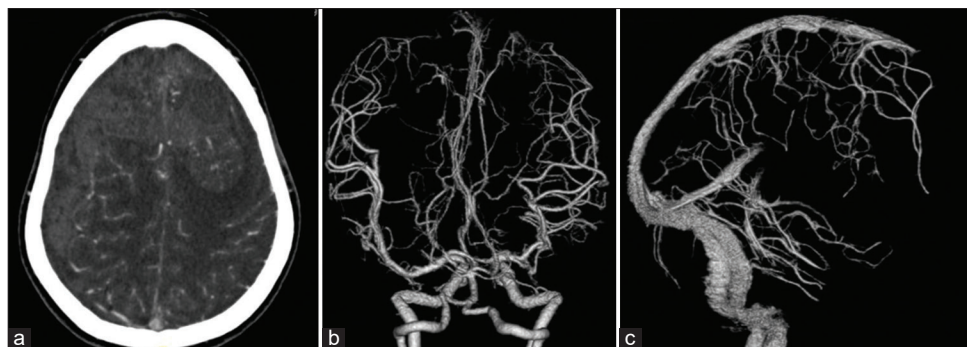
(a) Contrast-enhanced computed tomography (CT) reveals vascular structures within the mass lesion. (b) CT angiography reveals no aneurysm or arteriovenous malformation, and (c) the venous phase reveals occlusion in the anterior portion of the superior sagittal sinus.
